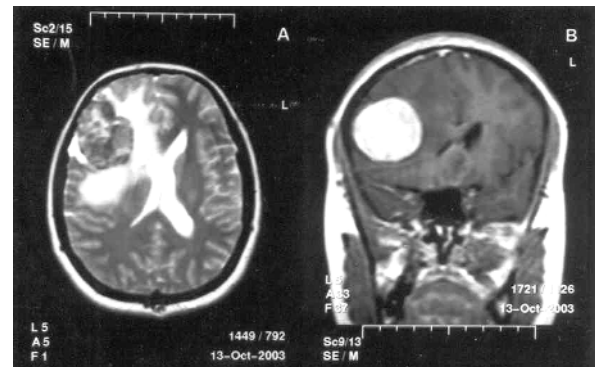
MRI appearance of dural-based right frontal lobe mass in coronal (A) and axial (B) sections
